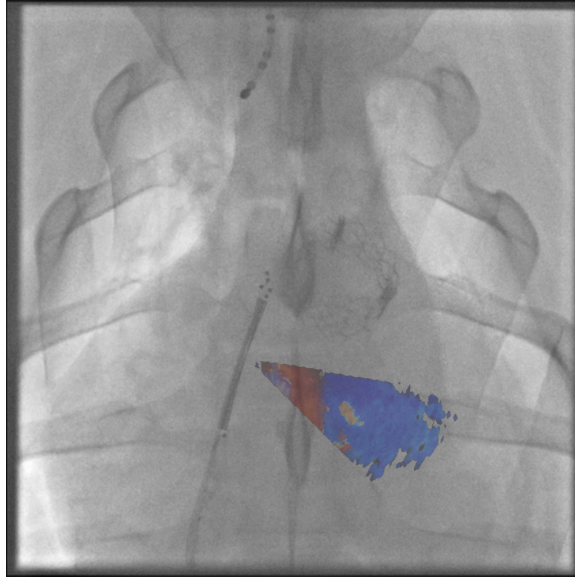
Interventional fusion of Doppler-mode volumetric ICE and X-Ray fluoroscopy.
